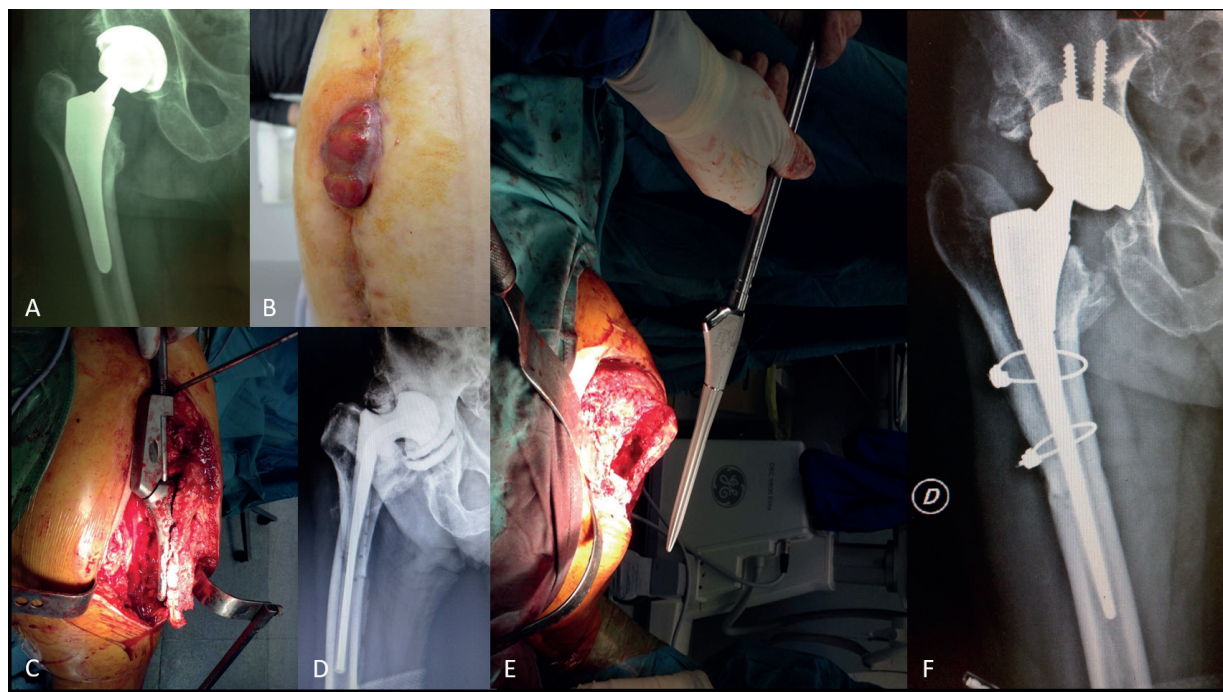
Two-stage revision surgery of a healed patient; a deep infection of a primary THA (A) was evident in the presence of an extruded and draining fistula (B); 1st stage implant removal required an extended trochanteric osteotomy (C) and the substitution with a long antibiotic gentamicin loaded spacer (D). 2nd stage after 3 months: a revision cementless stem was implanted in absence of any sign of infection. Two cerclages were necessary to manage the femoral osteotomy (E). 1-year radiographic control confirm a bony stable stem osseointegration and the osteotomy consolidation (F).
